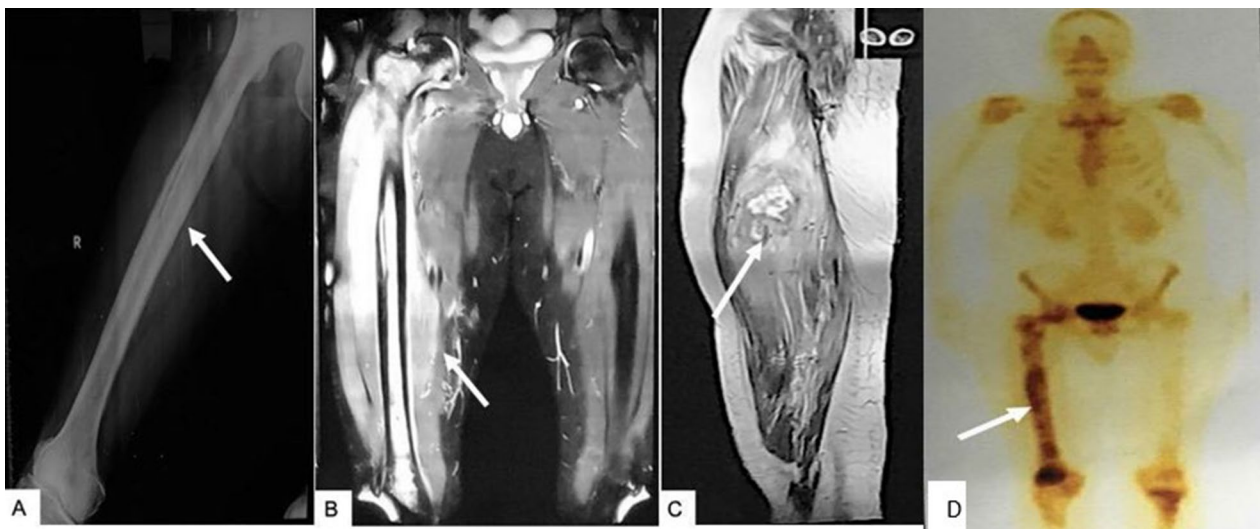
Radiograph of right femur A showing sclerosis involving the diaphysis of femur with cortical tunneling and mild adjacent soft tissue component (arrow). STIR (short tau inversion recovery) coronal MR image B showing hyperintensities in entire femur and adjacent muscles (arrow). T2W sagittal MR image C showing an intramuscular abscess with surrounding edema (arrow). Technetium-99 methylene diphosphonate (Tc-99 MDP) bone scan D—3 h delayed image showing diffuse tracer uptake in the entire right femur (arrow)
